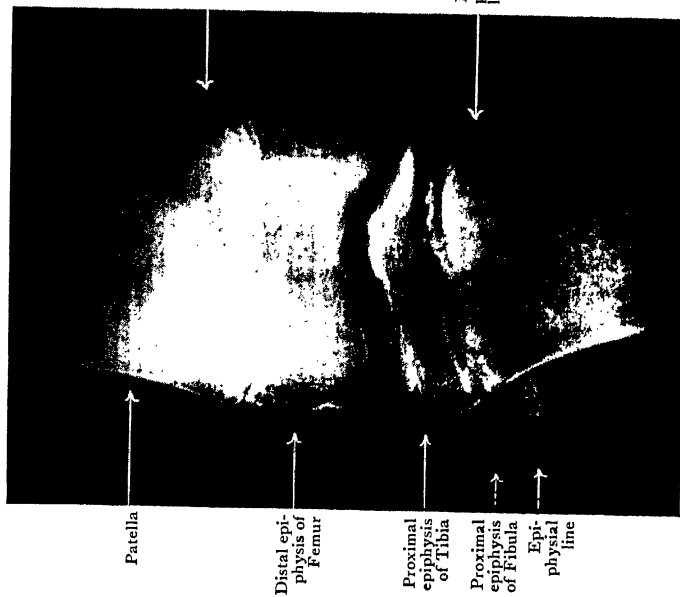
Radiograph of Knee of boy aged 12.
